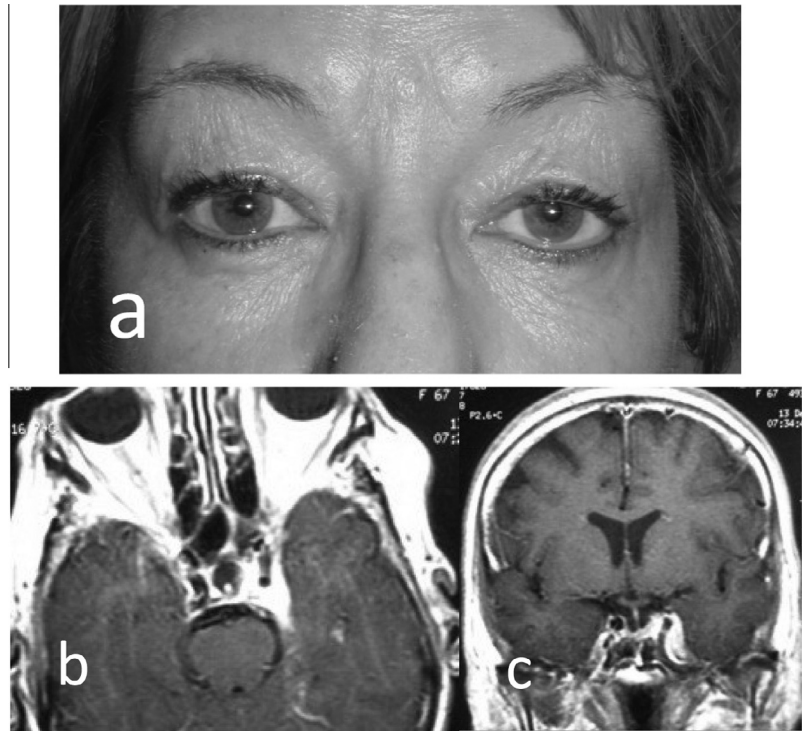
(a) Ptosis and miosis on LE (HS). MRI; (b) axial and (c) coronal views showing images compatible with cavernous sinus meningioma.
